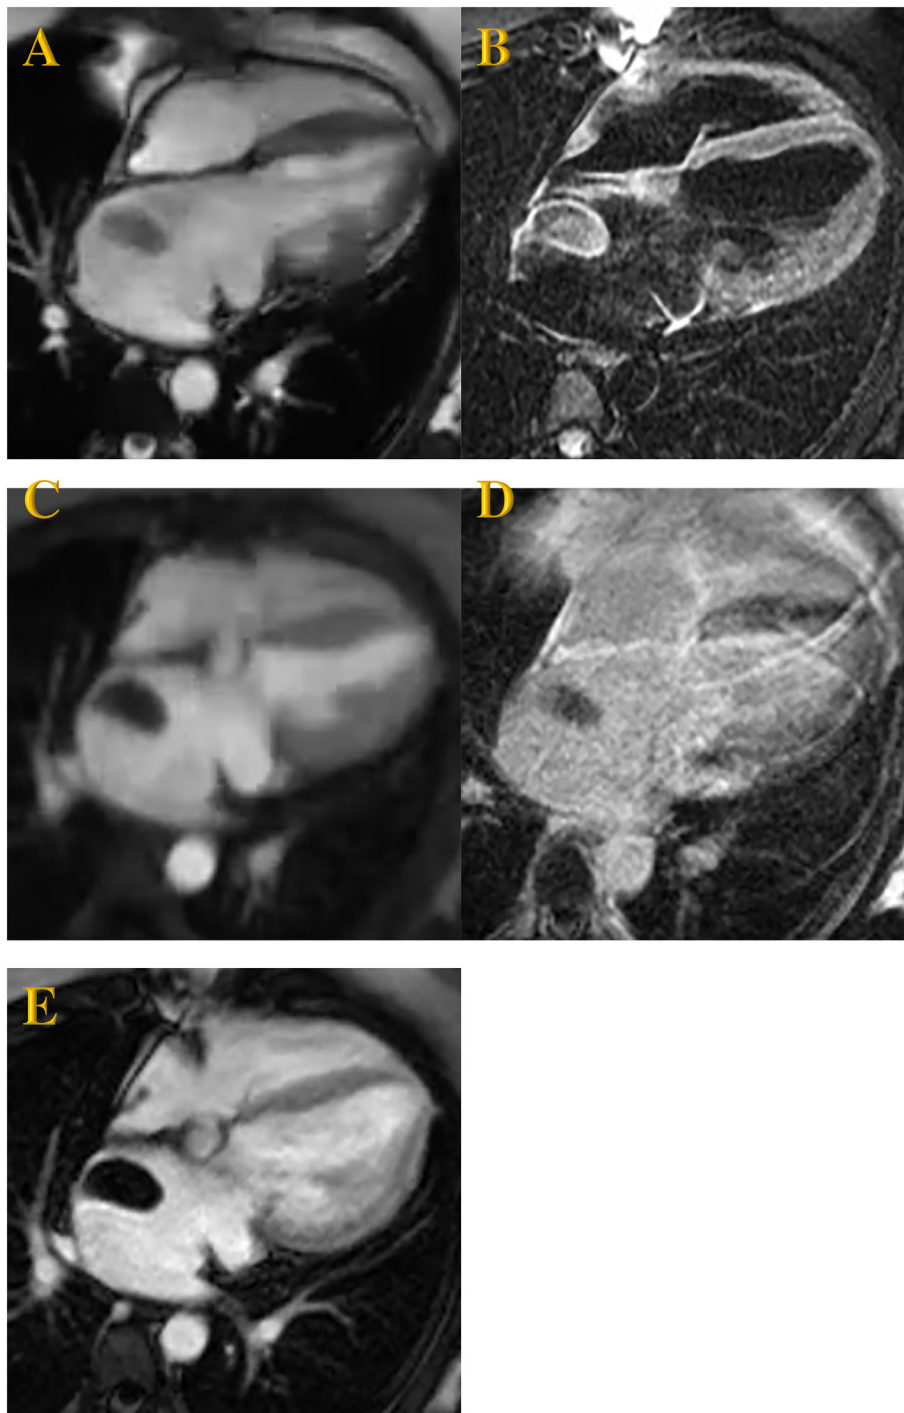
Mass in the left atrium arises from the interatrial septum adjacent to the fossa ovalis. The mass has heterogeneous signal intensity on bright blood sequence (image A) and heterogeneous high signal intensity on T2-weighted sequence (Image B). Post contrast sequence demonstrates heterogeneous enhancement with foci of enhancement and some area of non-enhancement (image C). Image D demonstrates the CT correlate of this mass on a CT chest angiography. Image findings are consistent with left atrial myxoma.
